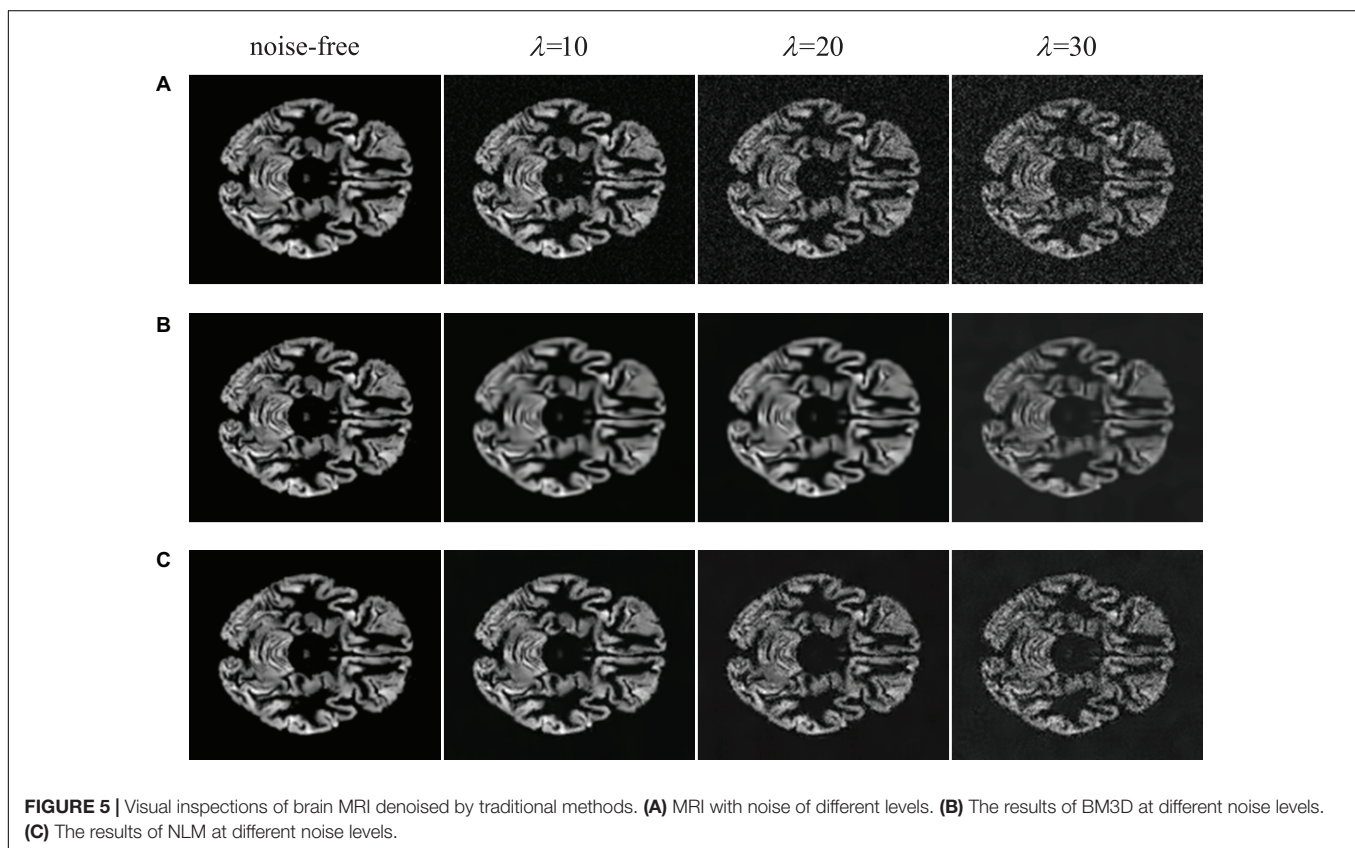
Visual inspections of brain MRI denoised by traditional methods. (A) MRI with noise of different levels. (B) The results of BM3D at different noise levels. (C) The results of NLM at different noise levels.
